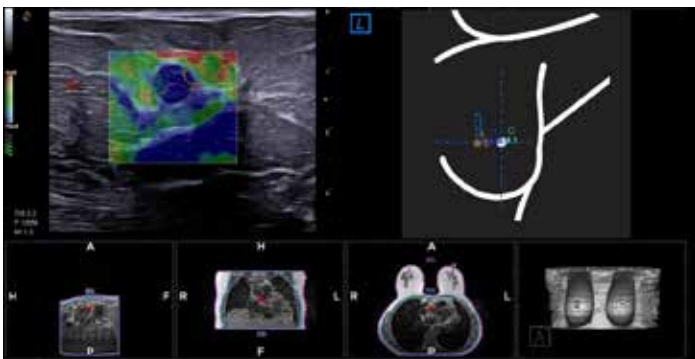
US Strain Elastography evaluation (ElaXto, Esaote) associated with BreastNav™ MRI technology
